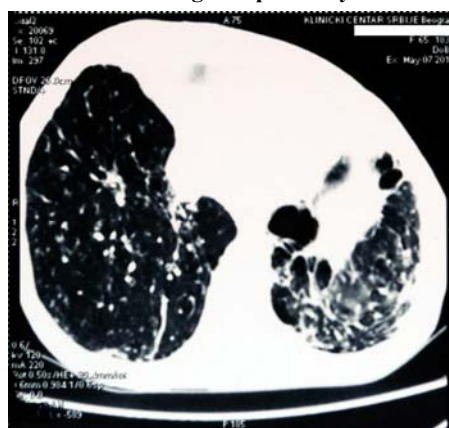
CT scanning showing bullous changes with bronchiectasis to the basal left, paratracheal lymph nodes 18 mm in diameter, bilateral pleural effusion, basal, organized, as well as diffuse lung reduction.
